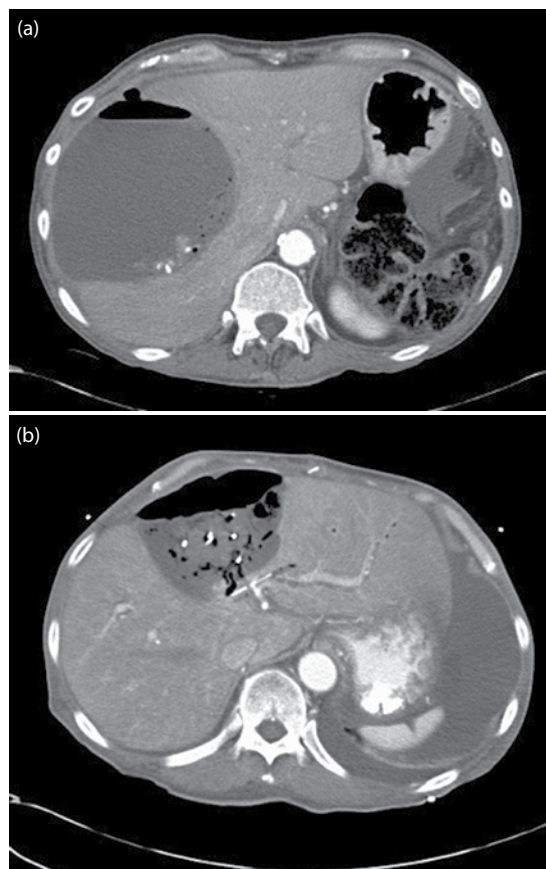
Postablation intrahepatic fluid collection versus intrahepatic abscess. (a) Postablation CT showing intrahepatic fluid collection with air-fluid level without infection that resolves without intervention. (b) Postablation CT showing an intrahepatic abscess with clinical and radiographic signs of infection requiring percutaneous intervention.
